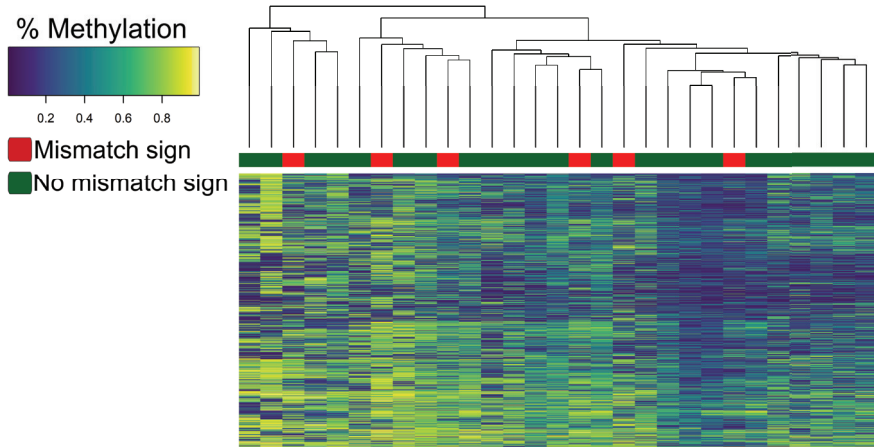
DNA methylation profiling for IDH-mutated astrocytomas, $n=29$. Unsupervised hierarchical clustering analysis does not cluster IDH-mutated astrocytomas with the T2-FLAIR mismatch sign (red) together. From Corell et al, *The clinical significance of the T2-FLAIR mismatch sign in grade II and III gliomas: a population-based study*, BMC Cancer 2020.
